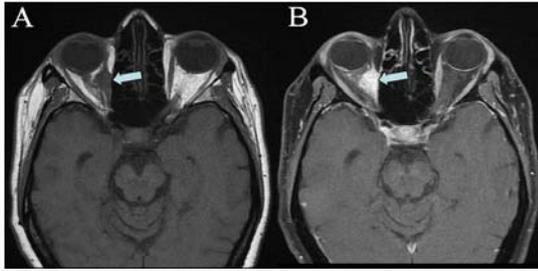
A) T1- MR image depicting the lesion at the time of first diagnosis, as an infiltrative solid nodule (arrow) located on the right orbit involving the medial rectus muscle. B) Post-contrast fat-suppressed T1 image shows enhancement of the lesion (arrow).
